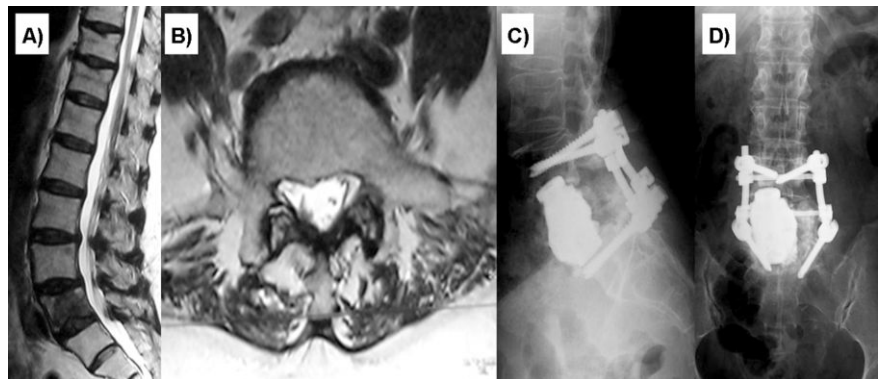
A 65-year-old female patient with lung cancer metastasis in her L5 vertebra (patient #3). A) Preoperative sagittal T2-weighted MR imaging of the patient; B) Preoperative axial T2-weighted MR imaging of the patient; C) Lateral radiographic view after the operation; D) Antero-posterior radiographic view after the operation.
